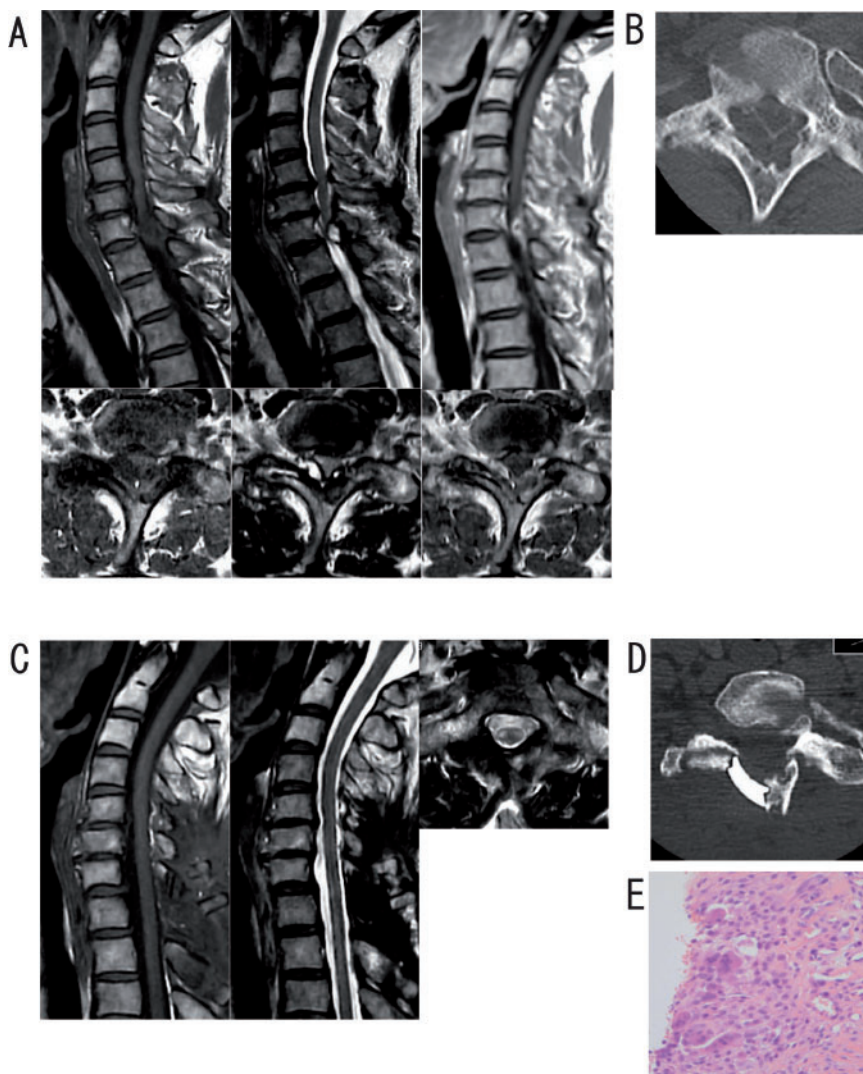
Case 1. (A) Sagittal (upper row) and axial (lower row) magnetic resonance images show an intraspinal cystic lesion located posterolaterally to the right of the spinal cord at the level of the interlaminar space of C7-T1, with marked compression of the neuraxial structure and peripheral signal enhancement after administration of gadolinium on T1-weighted images. (B) Computed tomography (CT) myelogram shows a mass compressing the spinal cord and bone erosion of the C7 lamina. (C) Post-operative magnetic resonance imaging after two years shows complete resection of the cyst and a decompressed spinal cord. (D) Plain CT reveals expansion of the cervical spinal canal. (E) Pathological examination showed the cyst to be composed of fibrous connective tissue without a discernible epithelial or synovial cell lining.
